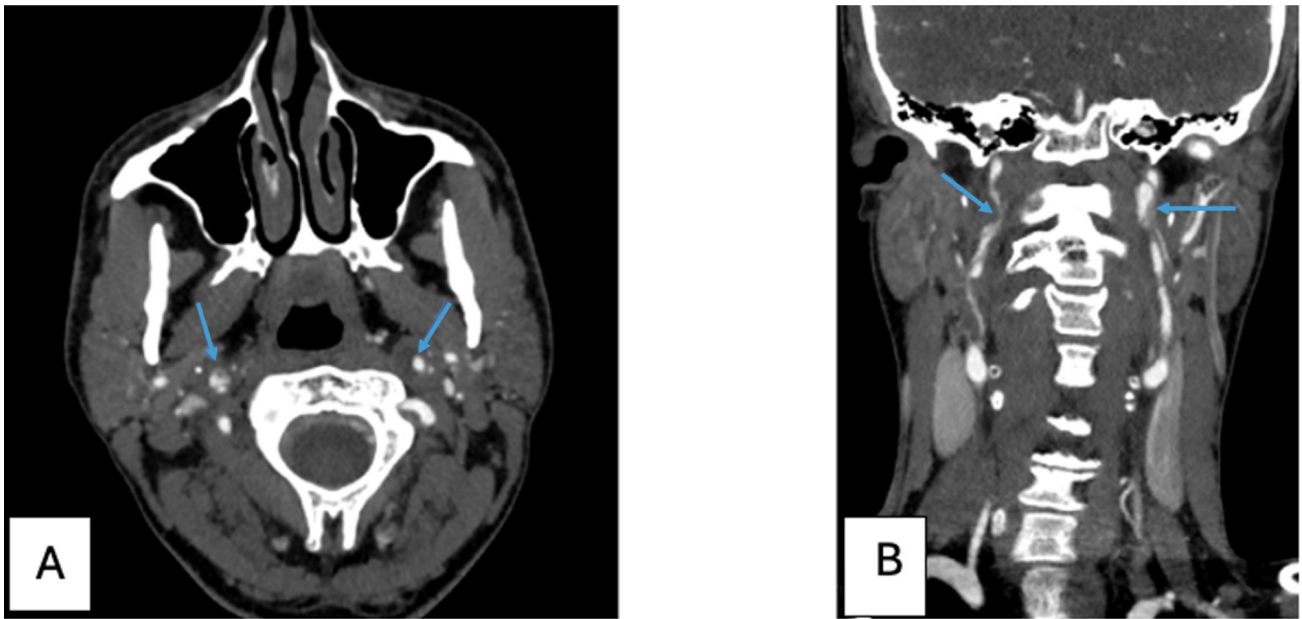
CT angiogram showing the new right internal carotid artery dissection. (A) Axial CT angiogram showing new right internal carotid artery dissection (right blue arrow) and relatively unchanged left internal carotid artery dissection (left blue arrow). (B) Coronal view of the CT angiogram showing new right internal carotid artery dissection (right blue arrow) and relatively unchanged left internal carotid artery dissection (left blue arrow).
